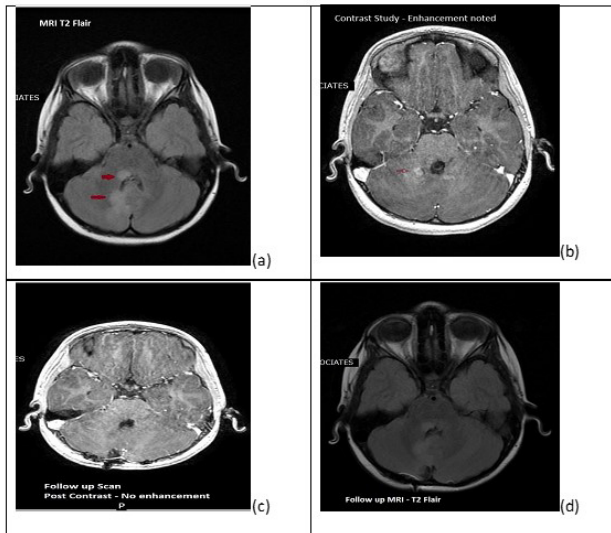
MRI images: (a)T2 sequence showing right tectal pons and medial cerebellum hyperintensities, (b)post contrast images showing enhancement in the corresponding locations, (c) follow up post contrast image showing no enhancement, (d)T2 Flair sequence on follow up showing hyperintensities in the same locations as in the earlier image.
